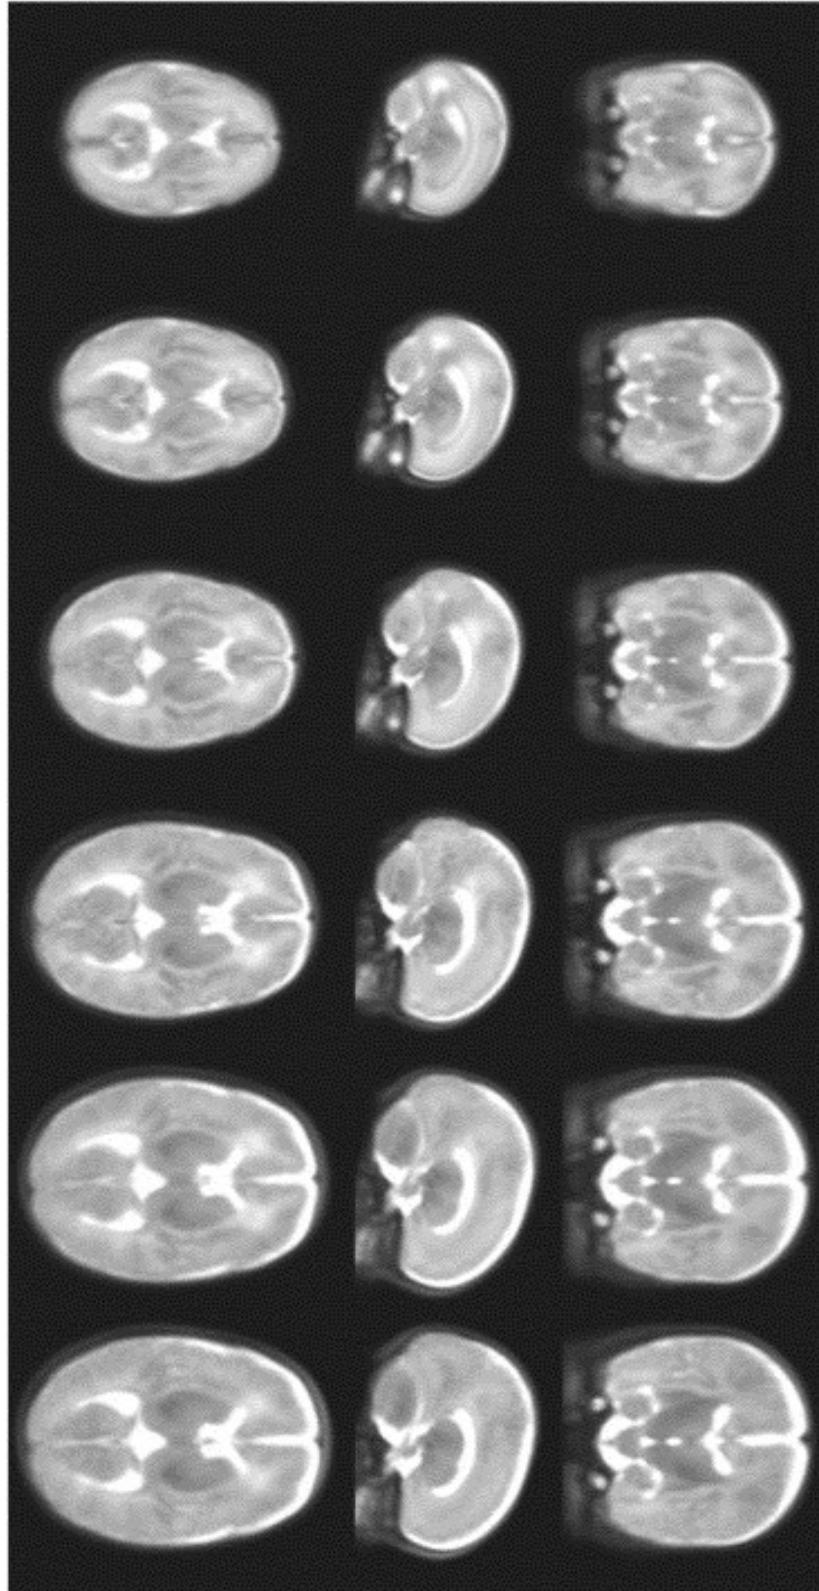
Intensity-averaged MRI intensity image 4D neonatal head models [164]. From left to right: atlas of 29, 32, 35, 38, 41 and 44 weeks old infants are shown in this figure.
